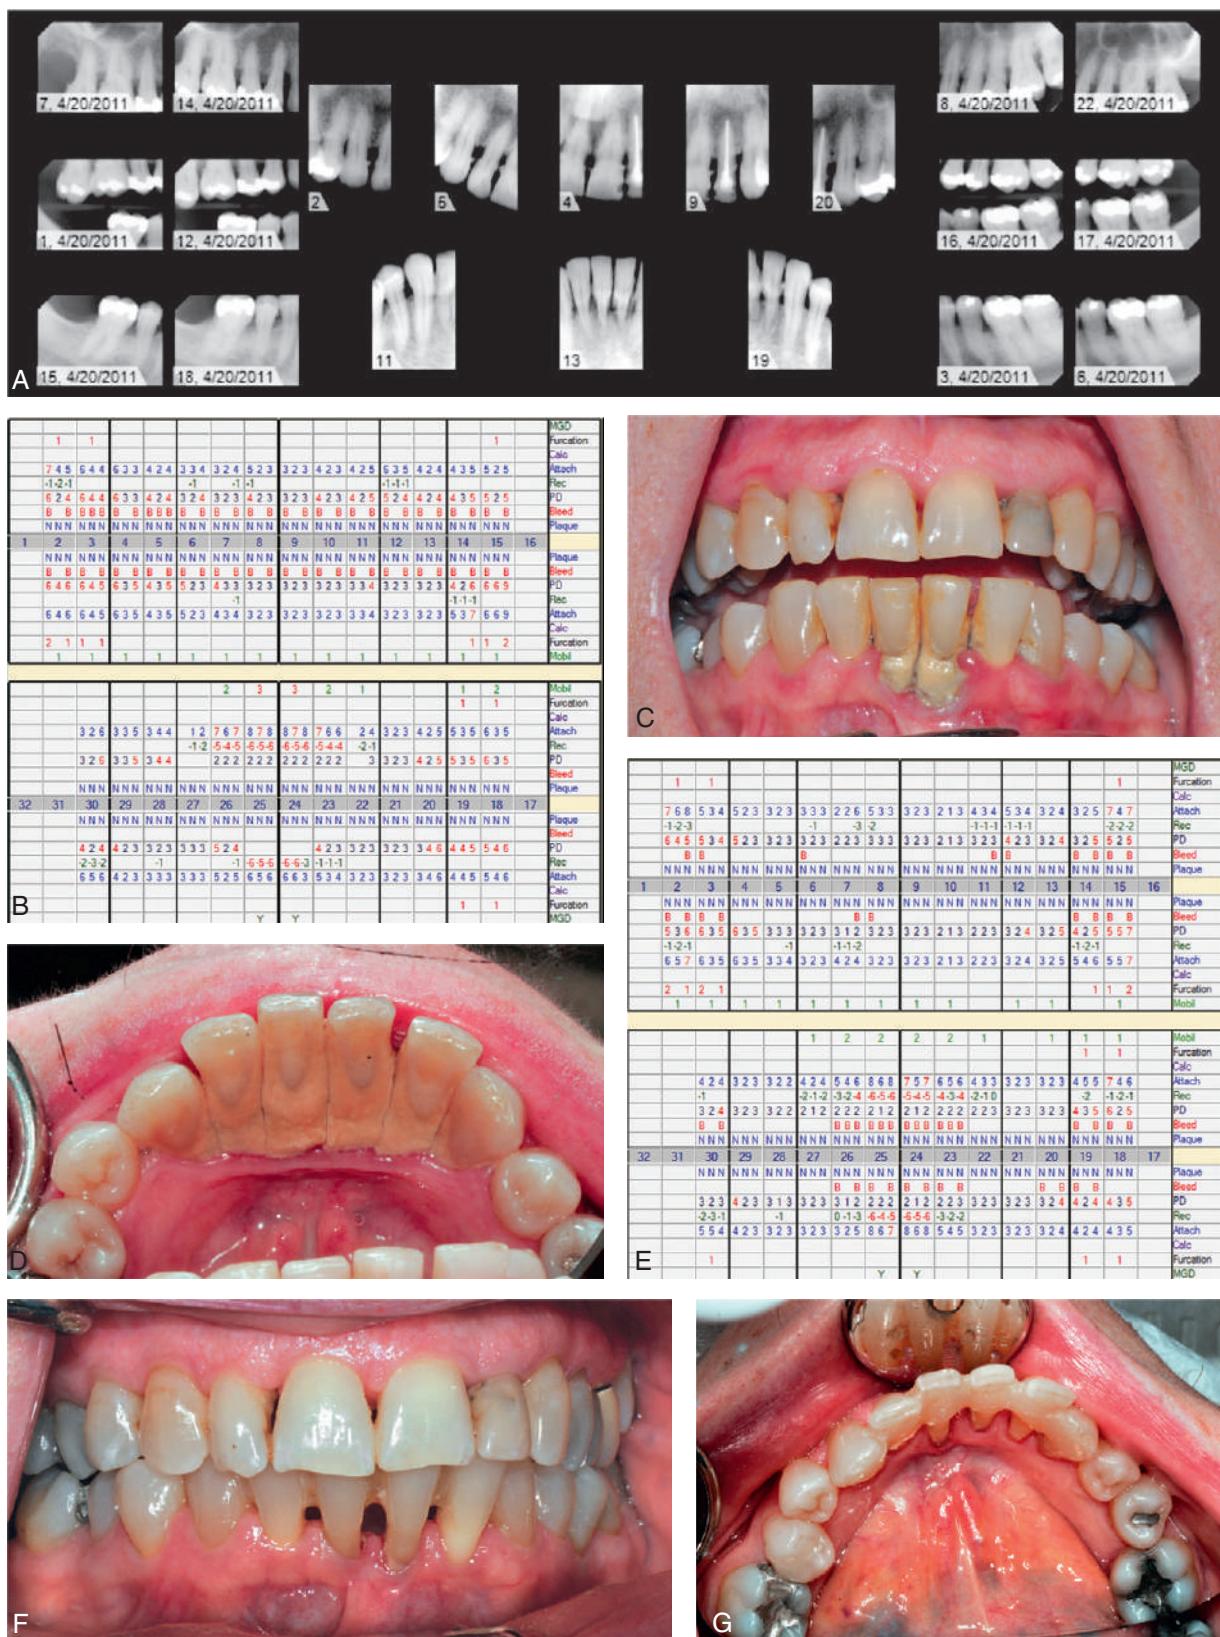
Periodontal charting showing resolution of periodontal infection with scaling and root planing (SC/RP) results in a reduction in inflammation and gingival recession. (A and B) Pre-SC/RP radiographs and data showing generalized moderate-to-severe periodontitis. (C and D) Initial presentation. (E) Post-SC/RP reevaluation data, demonstrating pocket reduction and gingival recession. (F and G) Post-SC/RP appearance, with clinical reduction in inflammation and gingival recession. (C, D, F, and G, Courtesy Dr. Spencer Shoff.)
